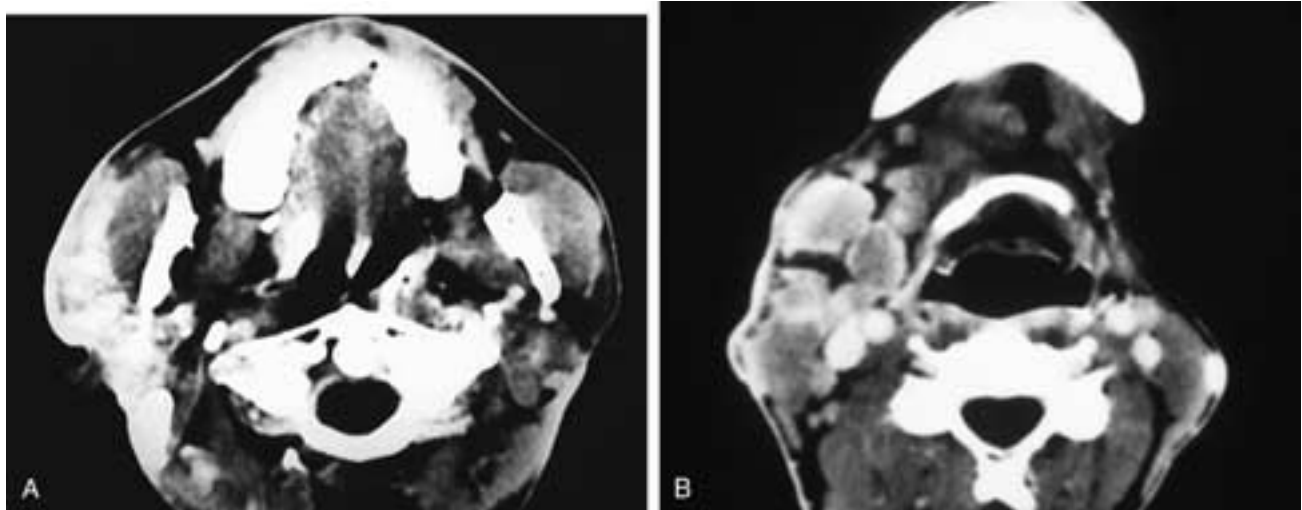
Axial contrast-enhanced CT scans through the level of the parotid glands (A) and more caudally in the neck (B) show an intensely enhancing infiltrative process involving the right parotid gland, the adjacent soft tissues, and the lymph nodes. This Asian male had Kimura's disease.
